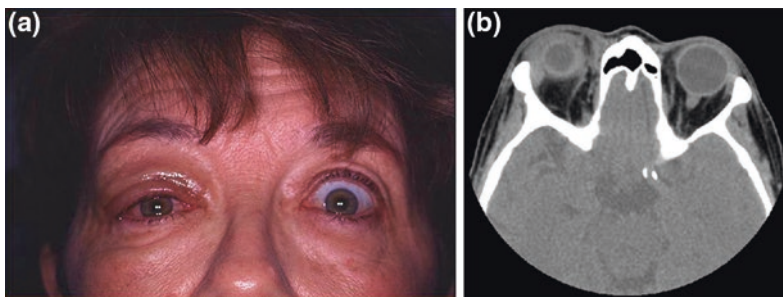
a A 50-year-old female presented with right upper eyelid swelling and redness over 4 weeks. There was no response to oral antibiotics. She felt otherwise well. Clinically she had swelling and erythema of the right upper lid, 3 mm of proptosis and slight underactivity in upgaze. There was a palpable mass in the area of the lacrimal gland that was non-tender. b Axial CT scan showing uniform enlargement of the right lacrimal gland without bone erosion or molding. A biopsy was performed and revealed a noncaseating type of inflammation consistent with Sarcoidosis. A systemic work-up did not reveal any other areas of involvement; the patient responded to prednisone but relapsed on a tapering dose and required methotrexate to settle the lacrimal gland inflammation
